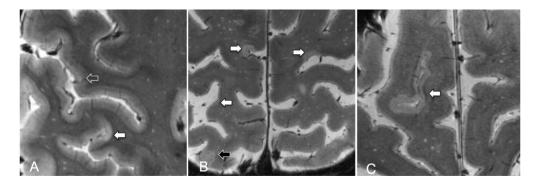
Examples of cortical lesion subtypes on 7 Tesla T₂*-weighted MRI images. (A-C) Images show examples of multiple MS lesions (white arrows showing subpial lesions; open arrow showing type 2 intracortical lesion; black arrow showing leukocortical lesion)
